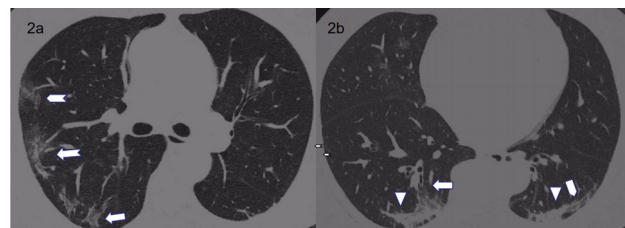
A 63-year-old female patient with nonsevere COVID-19. A CT scan showed multiple patchy pure GGO (\square), GGO with fine reticulation (\square) and GGO with focal consolidation (\square) in the subpleural area of the inferior lobe of the right lung, and the long axis was parallel to the pleural surface (2a). Streak shadows (\square) and patchy consolidation (∇) and GGO with fine reticulation (\square) were observed in the subpleural area of the inferior lobe of the bilateral lung (2b), and pure GGO in the subpleural area of the middle lobe of right lung (2b).
